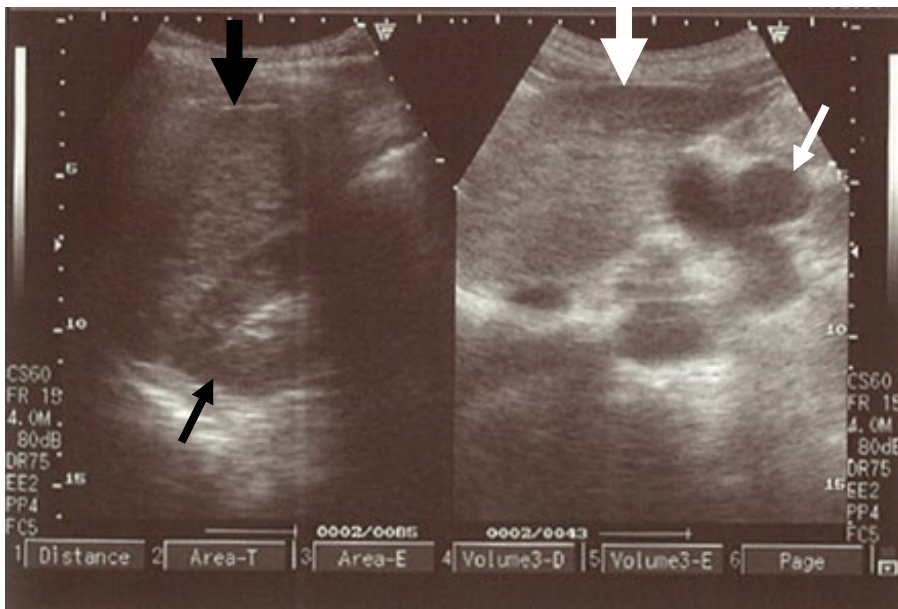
Abdominal sonography, right panel: right axillary line sagittal view shows right lobe of liver (black thick arrow) and right kidney (black thin arrow), left panel: mid-line sagittal view shows left lobe of liver (white thick arrow) and tortuous tube like structures near liver (white thin arrow).
